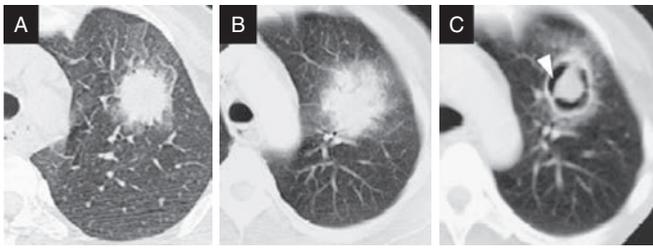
Radiographic evolution of invasive pulmonary aspergillosis in a neutropenic patient. (A) Early halo sign of ground glass opacity surrounding nodular lesions. (B) Nonspecific infiltrate of increased diameter. (C) Air crescent sign observed with neutrophil recovery, cavitation of infected lung in walled off cavity with air (arrowhead).
